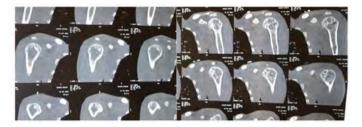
CT scan of the shoulders showing well-limited osteolytic formations with clear contours, respecting the cortex, and homogeneous compartmentalized fluid content. Metaphyso-epiphyseal locations. Typical SBC appearance.
